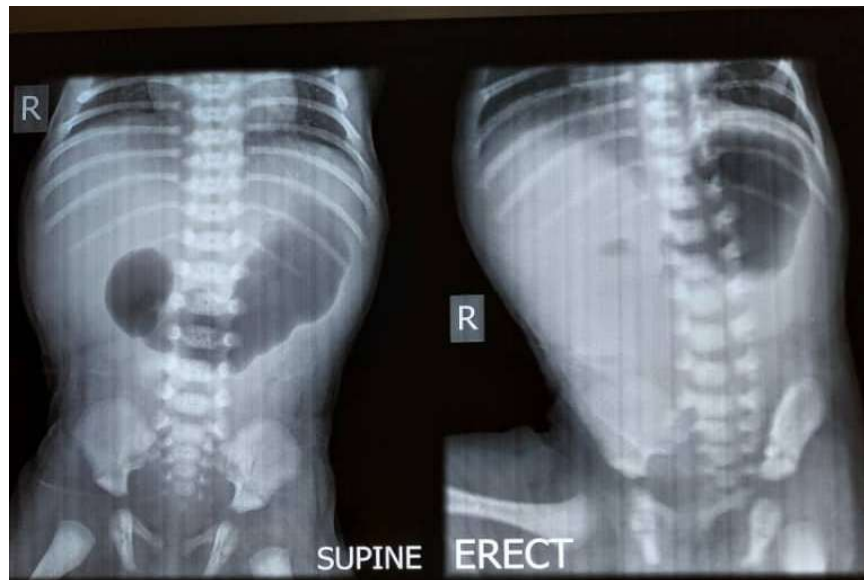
PLAIN ABDOMINAL RADIOGRAPHS SHOWING DOUBLE BUBBLE SIGNS
